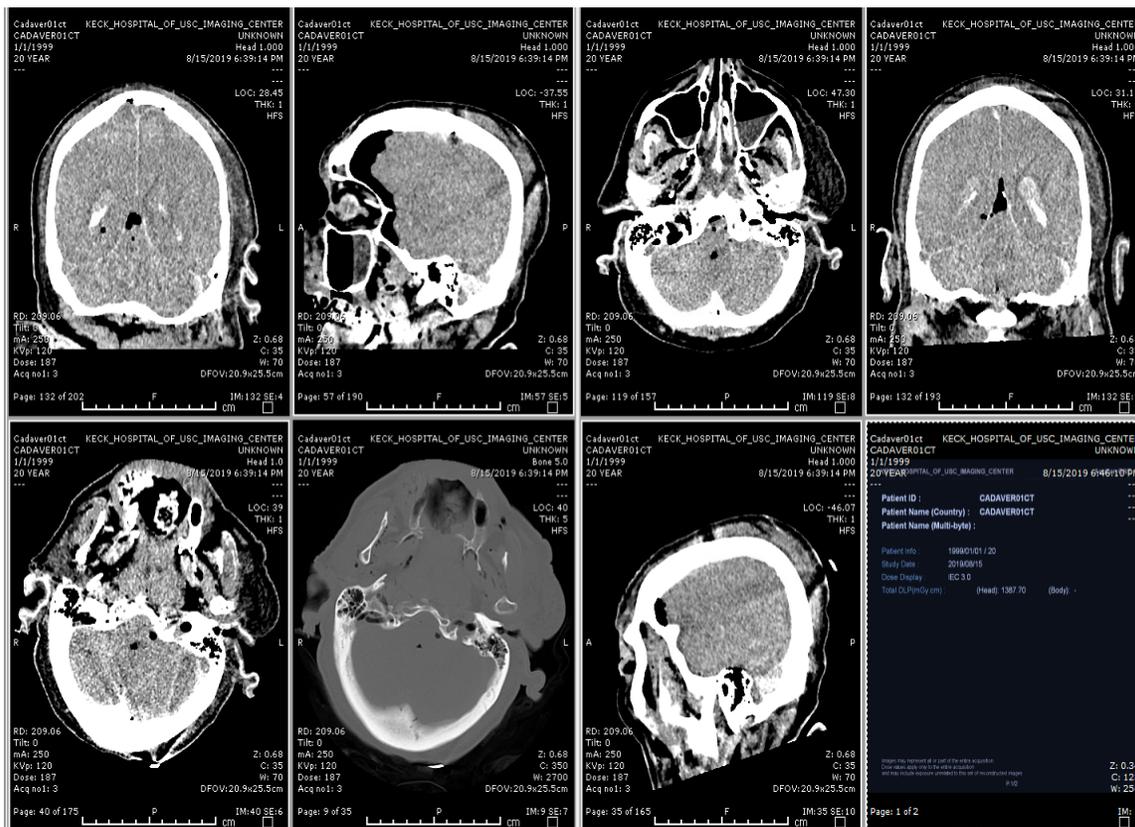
CT imaging in all dimensions, in addition to bone contrast enhancement.
